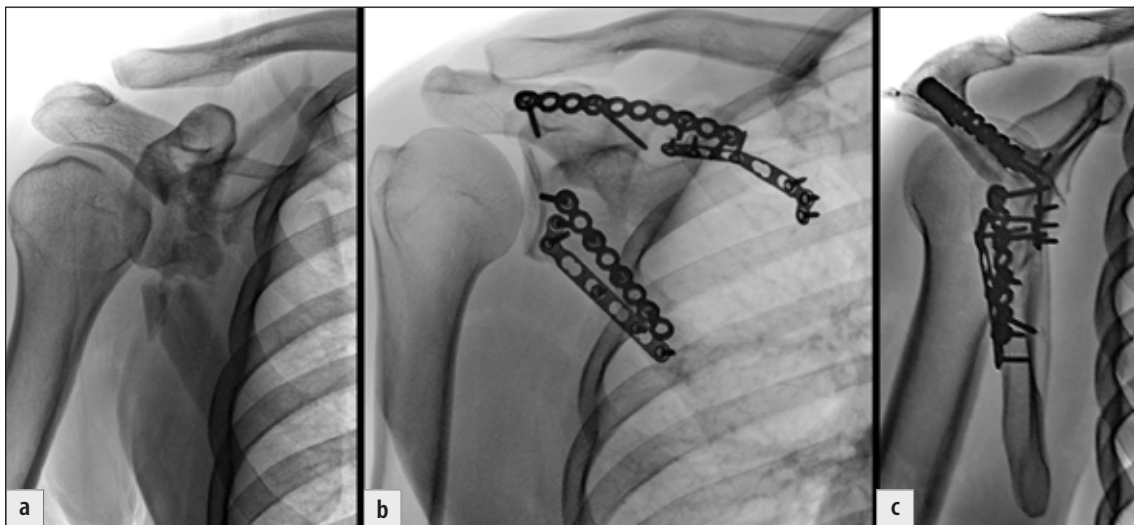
Radiological follow-up: a) post-injury radiograph; b+c) postoperative radiographs.
